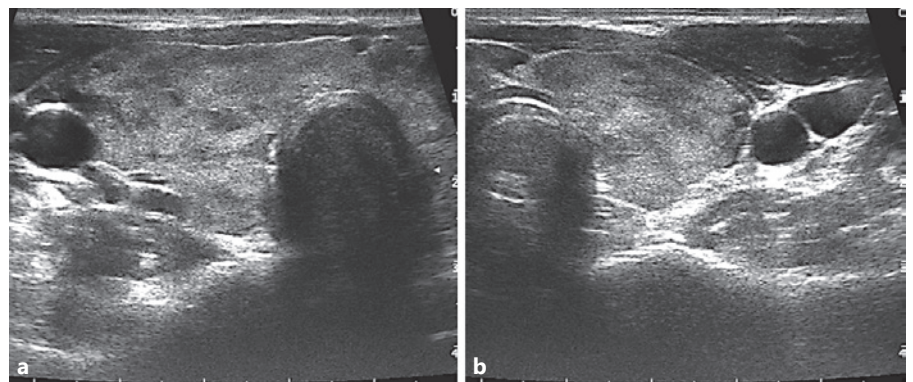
Ultrasound examination of the thyroid showing an inhomogeneous, hypoechoic, honeycomb-like pattern. a Right lobe. b Left lobe.
